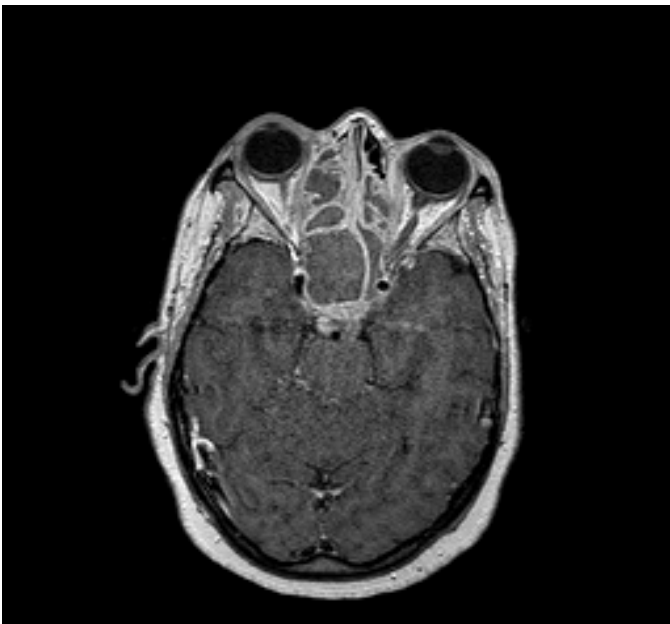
Post op MRI - Post IV Gadolinium T1 weighted Axial images showed only minimal thickening of the mucosa and polypoid change confined to the right middle turbinate
